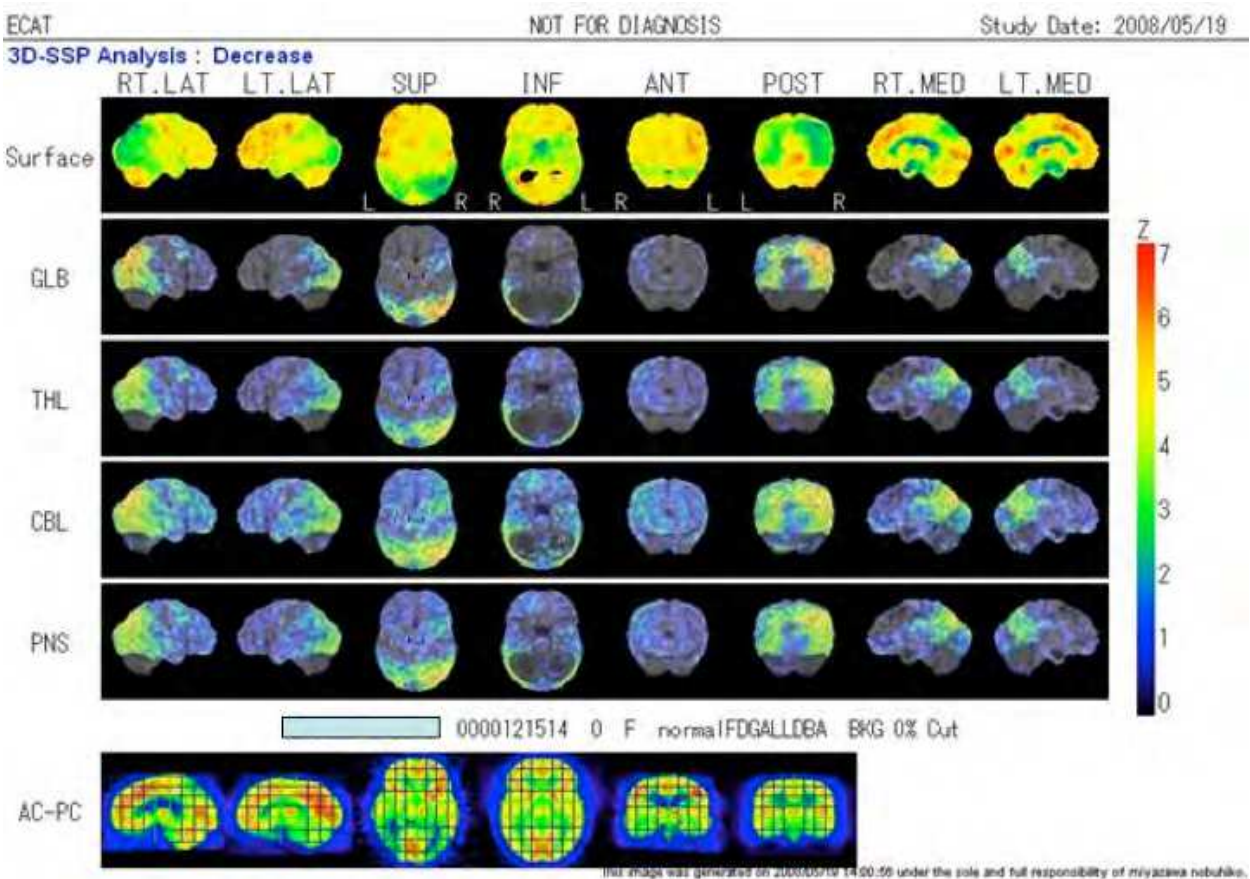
FDG-PET study of AD patients using 3D-SSP (Minoshima). Z-score mapping compared with normal controls showed decreased glucose metabolism in the bilateral precuneus, posterior cingulate, and temporo-parietal cortices, which is not clearly visible on normal scans by the visual method.
